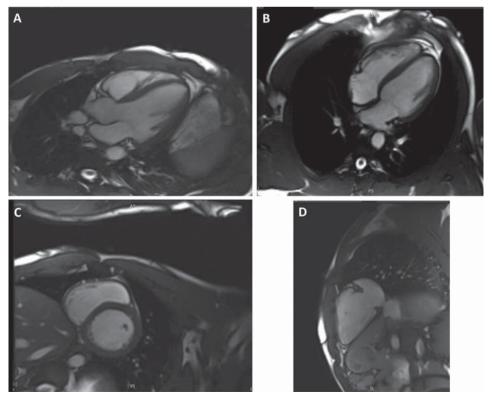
Cardiac Magnetic Resonance Imaging with three chamber (A), four chamber (B) and short axis views showing normal left ventricular function, without late Gadolinium enhancement. The right ventricle view (D) with normal aspect, without scar or criteria for arrhythmogenic dysplasia.
